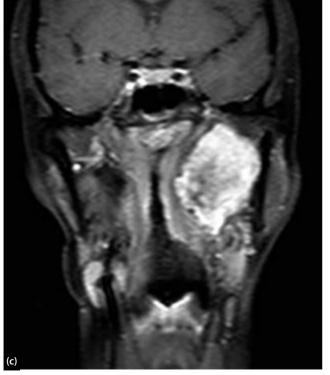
(a, b) Contrast-enhanced CT images of deep lobe PA; (c, d) Post-gadolinium, fat-saturated MR images of deep lobe PA.
